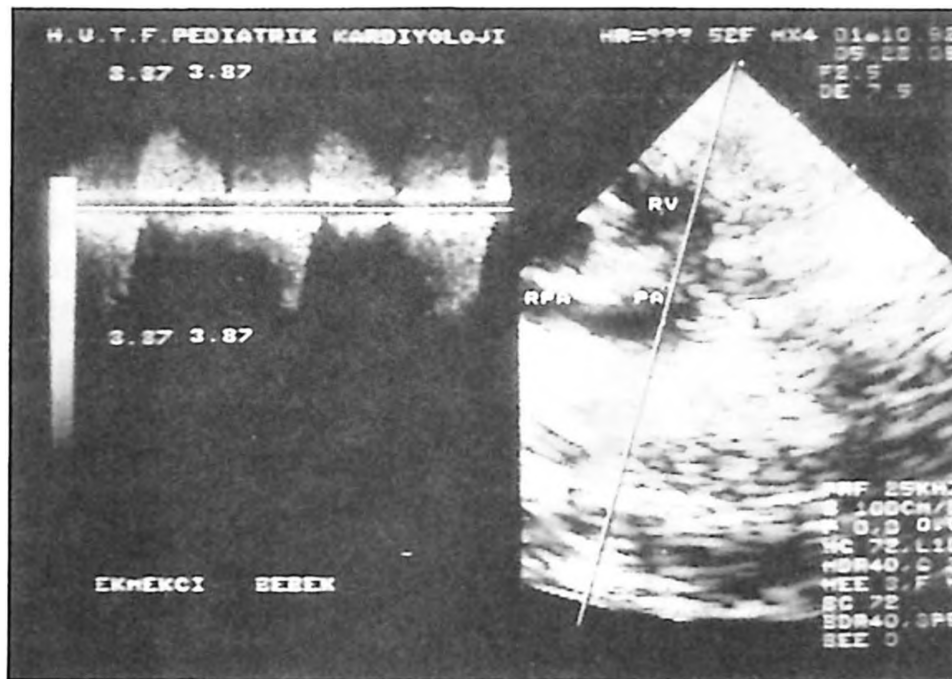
The echocardiographic appearance of the patient. It shows enlarged main and right pulmonary arteries and absence of the left pulmonary artery. Doppler echocardiography demonstrates systolic flow with an important gradient across the right ventricular outflow tract and diastolic flow.
